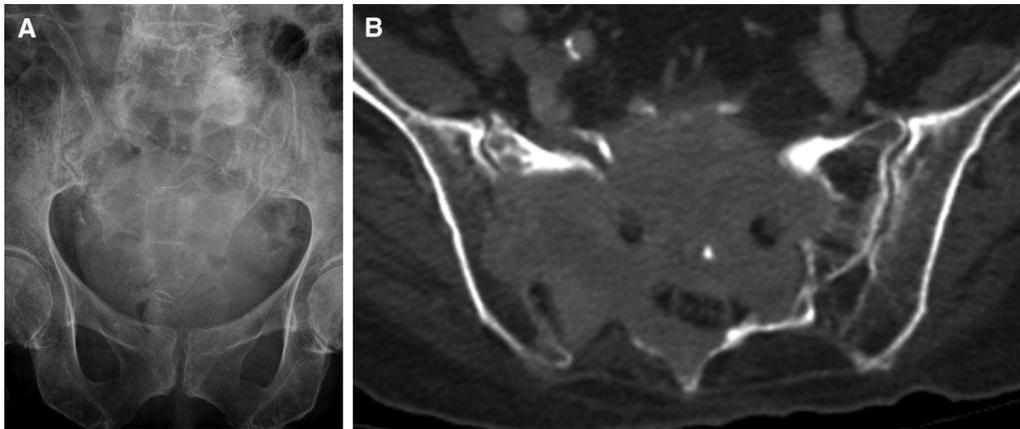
Sacral plasmacytoma. (A) Pelvic radiograph performed as part of a skeletal survey in a patient with monoclonal gammopathy shows an ill-defined lucency within the sacrum. (B) Axial computed tomography with bone windows shows a destructive soft tissue lesion within the sacrum, extending to involve the right sacroiliac joint. Following biopsy, this was confirmed to be a plasmacytoma.
